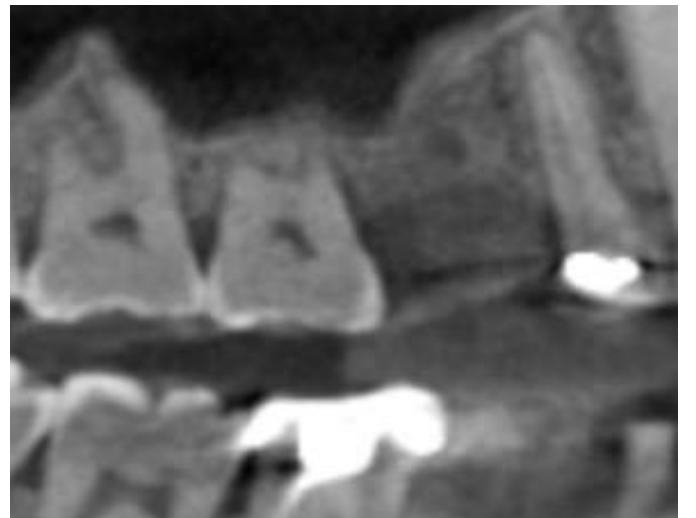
6th month post-operative CBCT
